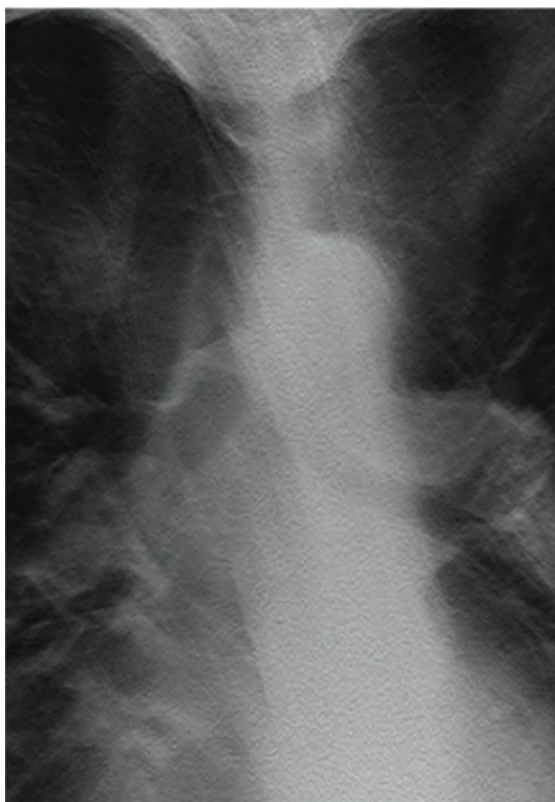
Adult with chronic obstructive pulmonary disease following left upper lobe EBV placement. Conventional chest radiograph (A) following left upper lobe EBV placement. Postprocedural digital tomosynthesis image (B) following EBV placement enhances demonstration of left apical lucency consistent with postprocedural pneumatocele (black arrow). Note improved visualization of the EBV within the left upper lobe airways (white arrow). Coronal chest CT reformation (C) following EBV placement confirms the digital tomosynthesis diagnosis of postprocedural pneumatocele.
